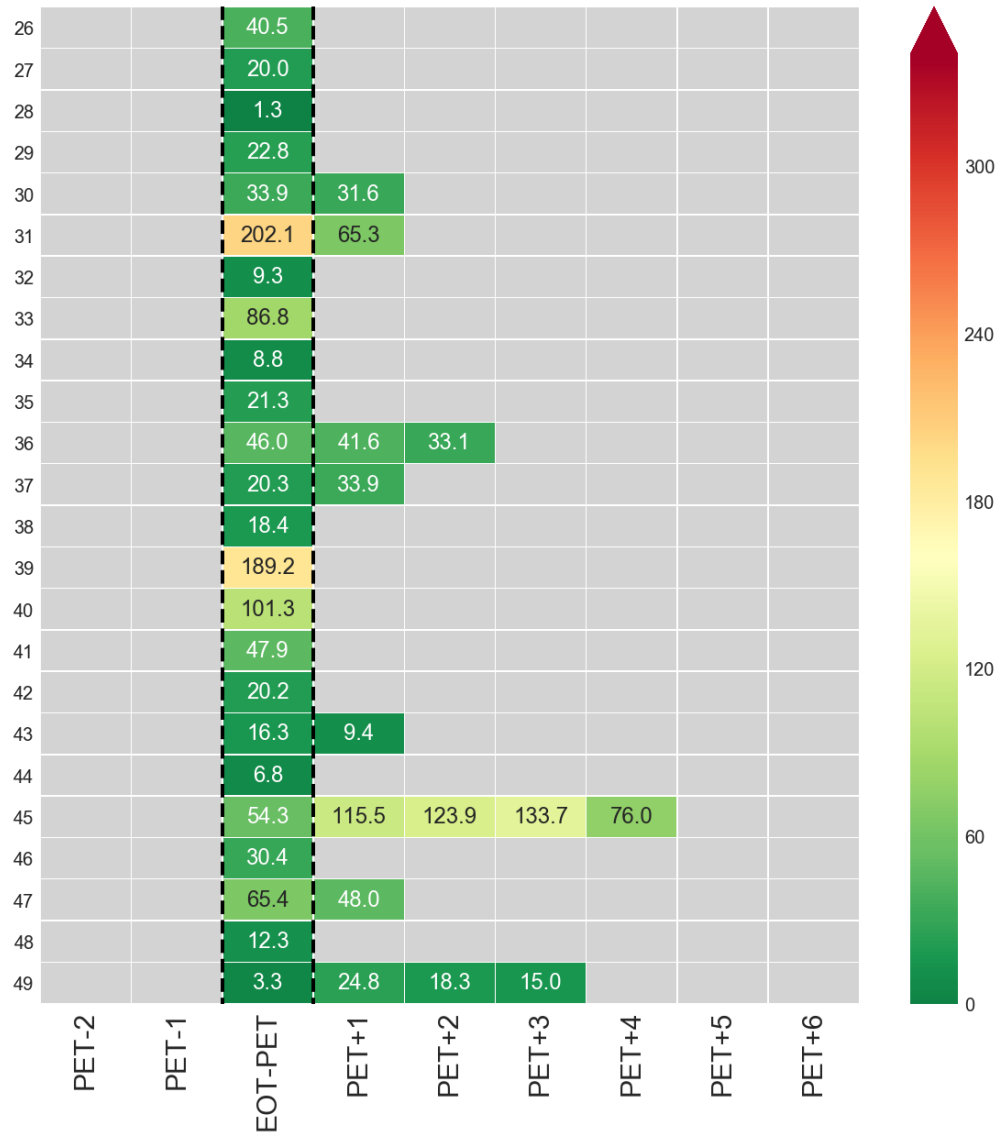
Total lesion glycolysis in negative EOT FDG-PET non-progressing NCI patients.
